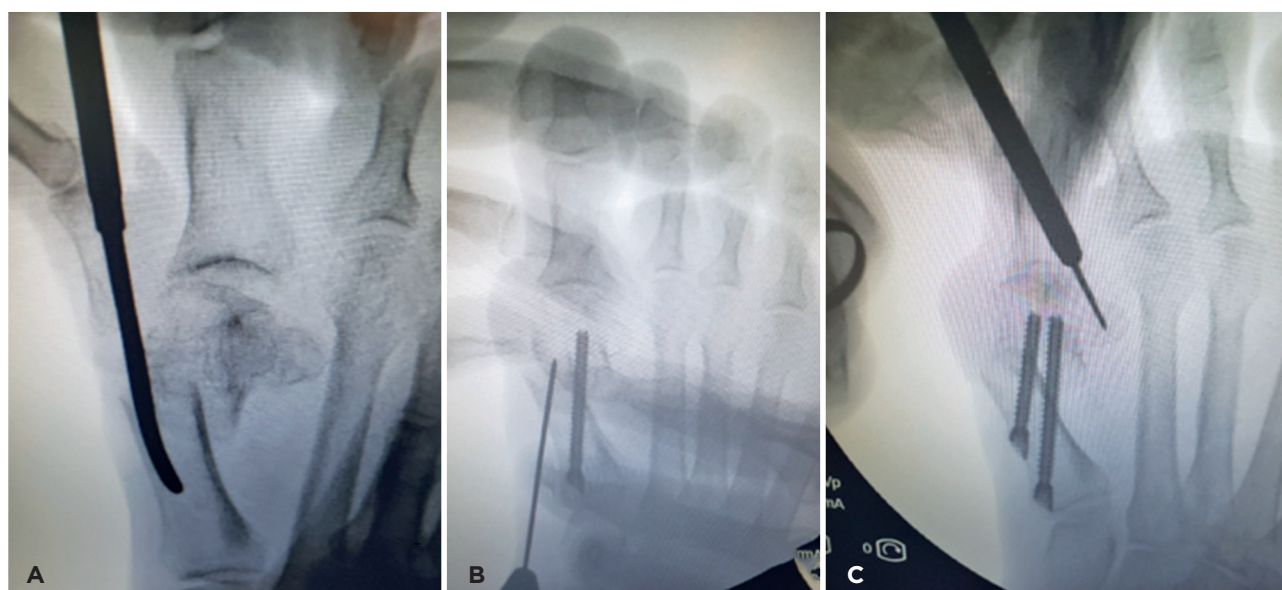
Intraoperative radiographs of the MICA technique. (A) The lateral displacement of the first metatarsal head, (B) the guidewire passage of the second screw, (C) osteotomy already fixed, preparing to perform the tenotomy of the adductor of the hallux.
